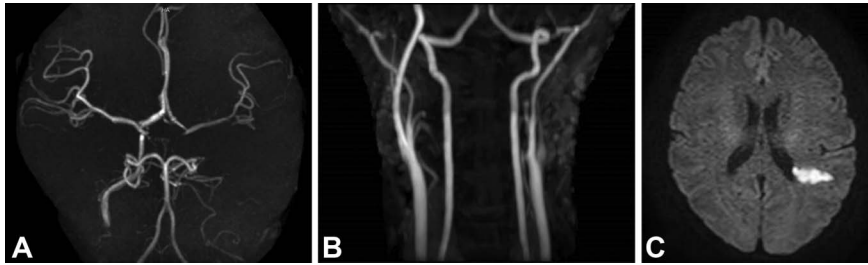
MRA and MRI at the initial examination. A. MRA revealed stenosis of the middle cerebral arteries. B. MRA revealed stenosis of bilateral ICAs. C. MRI revealed cerebral infarction.
